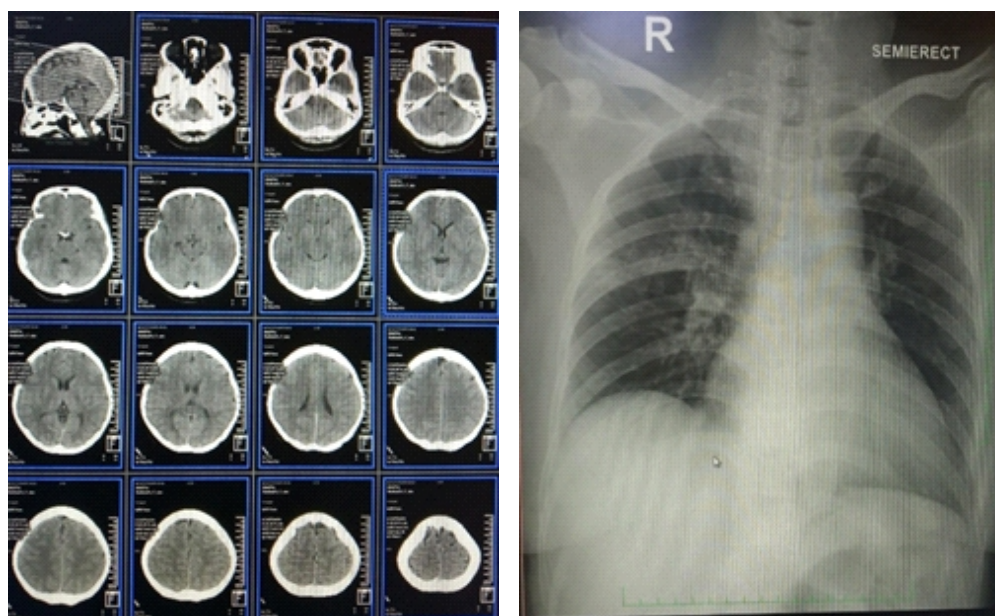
Head CT Scan results and Ro Thorax Case 1
